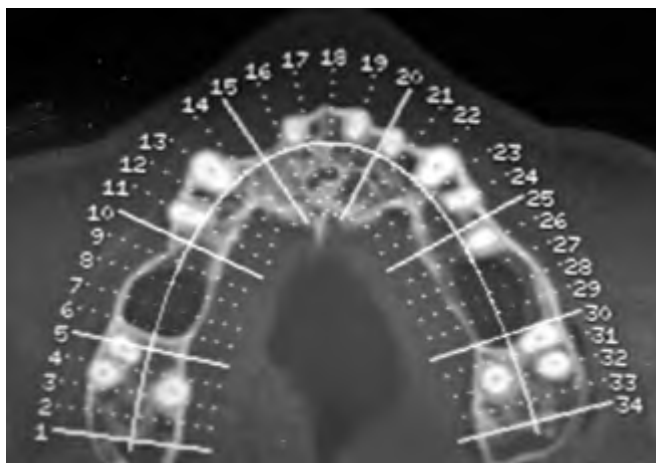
Preoperative CT scan (maxillary occlusal view). This slice was taken apical to the cemento-enamel junctions (CEJs) of the maxillary molars. The three roots of the molars were clearly visible. The radiolucencies between the molars and the first premolar on the patient's right side, and the second premolar on the patient's left side indicated the vertical depth of the sinus pneumatization.
